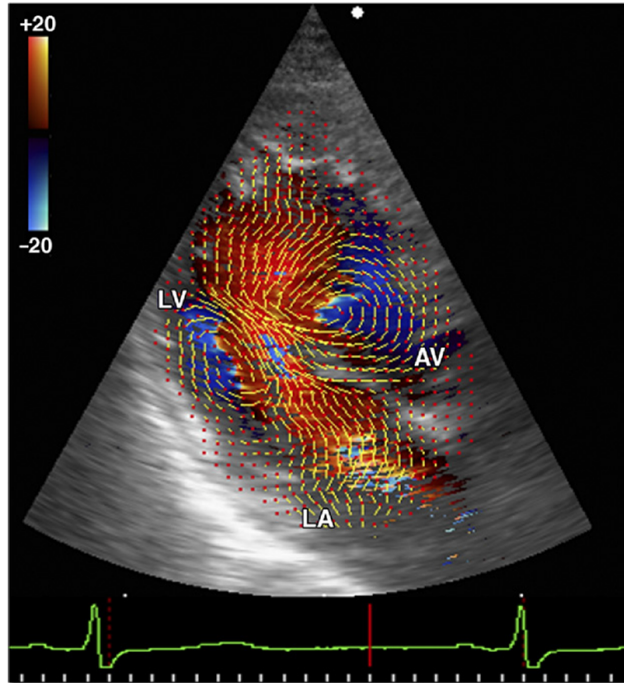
Flow velocity vector fields obtained by vector flow mapping. The flow velocity fields are superimposed on the color Doppler images [156].
